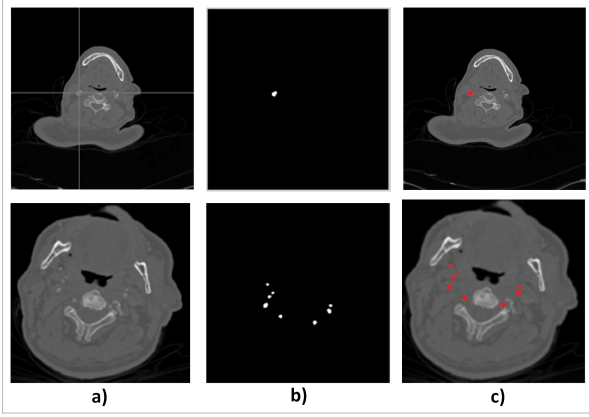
Region growing segmentation in CTA image
